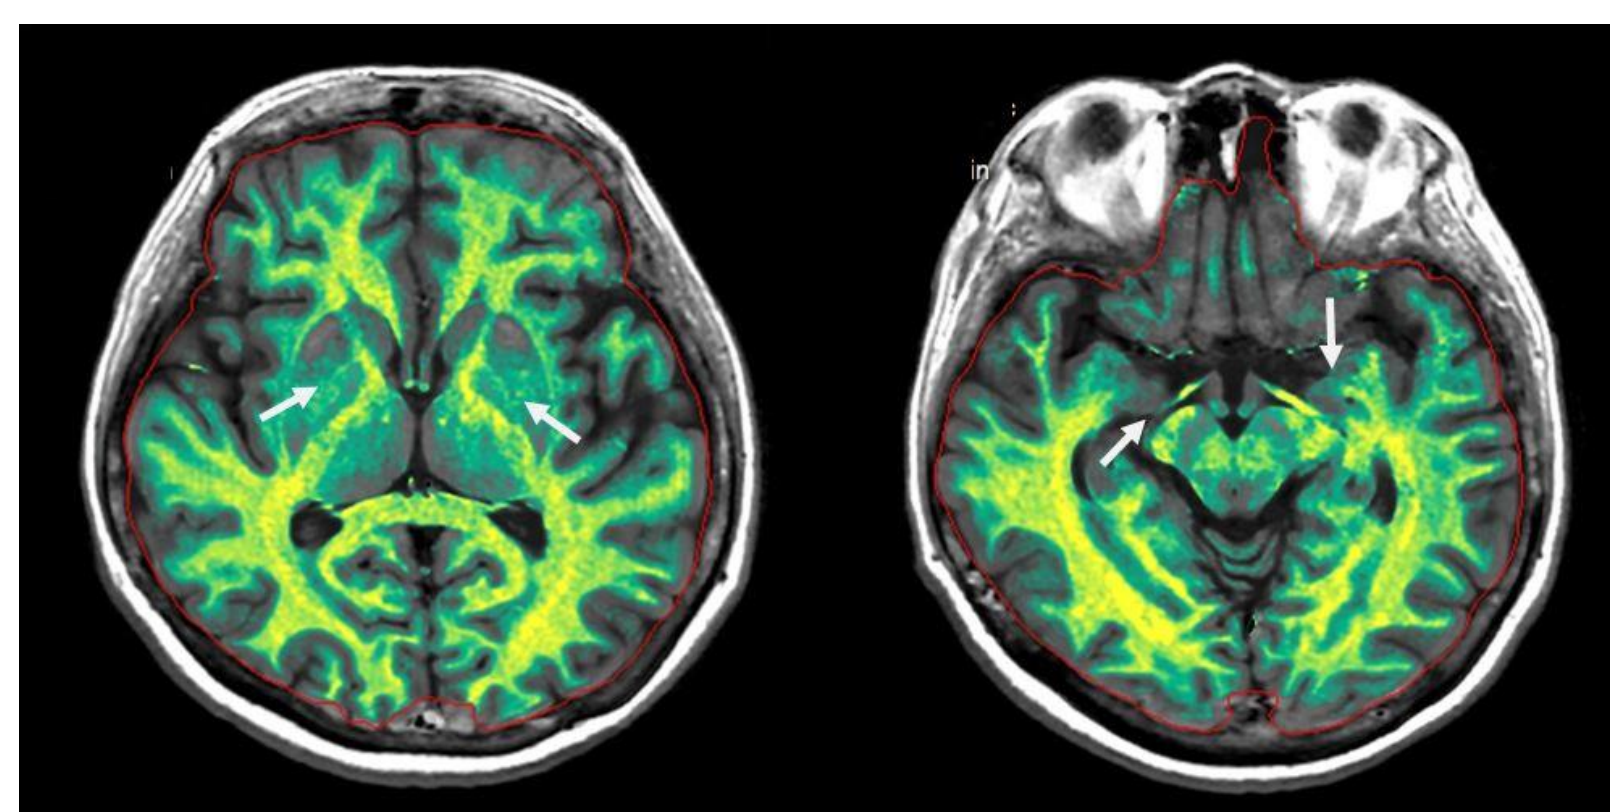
Segmental images of synthetic MRI show myelin loss on both anterior basal ganglia and hippocampi (white arrows).
